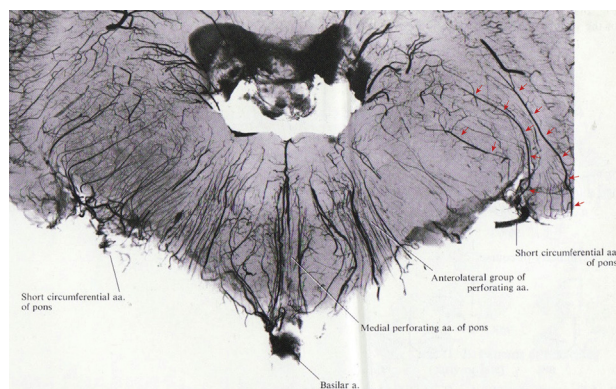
Radiograph of perforating vessels of a section of the pons and middle cerebellar peduncle (MCP) after arterial injection of the vertebrobasilar system. Perforating vessels at the cranial nerve VII–VIII nerve root entry zone enter the left MCP (*red arrows*) and traverse the parenchyma and terminate in the mid-MCP or near the fourth ventricle in the region of the lacunar infarctions, as seen in patients 1 and 2. (Reprinted with permission from Salamon G, Huang YP, *Radiographic Anatomy of the Brain*, Berlin: Springer-Verlag, 1976.)
